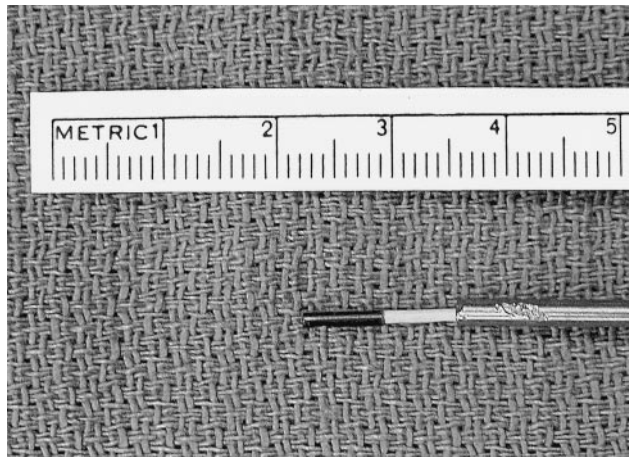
The 1-mm, 20-MHz Doppler probe is quite flexible and can be passed through a small metal suction tip to provide stability.
